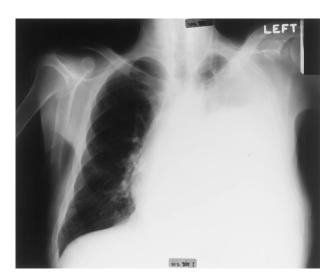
A chest radiograph showing near complete collapse of the left lung.
